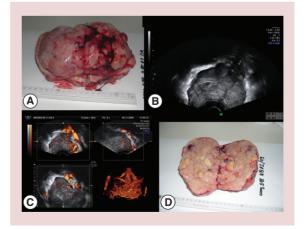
Ovarian dysgerminoma. (A) External surface; (B) B-mode; (C) 3D color Doppler, and (D) internal macroscopy of an ovarian dysgerminoma
